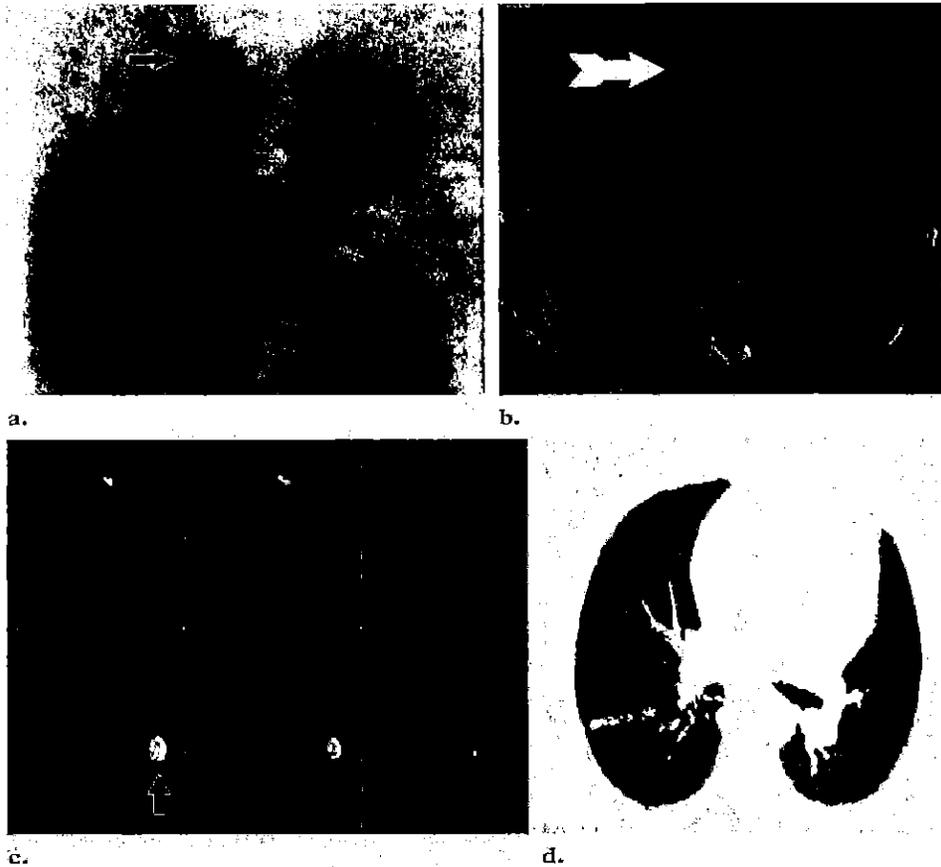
Abnormal extracardiac uptake on myocardial perfusion images. (a) Myocardial perfusion SPECT image of a 63-year-old man with episodic chest pain shows focal uptake medial to the heart (arrow). (b) Low-dose nonenhanced SPECT/CT image shows that the uptake corresponds to a mediastinal mass (arrow), a finding suggestive of a malignant process. Biopsy demonstrated an incidental malignancy. (c) Myocardial perfusion SPECT images, obtained in a patient with multiple cardiac risk factors who underwent pharmacologic stress technetium 99m (^{99m}Tc) tetrofosmin imaging, show a focus of activity (arrow) lateral to the heart on the resting images. (d) CT image shows no abnormality. No defect was identified on subsequent stress images; the focal activity was thought to be a false-positive finding related to a radiolabeled blood clot.
